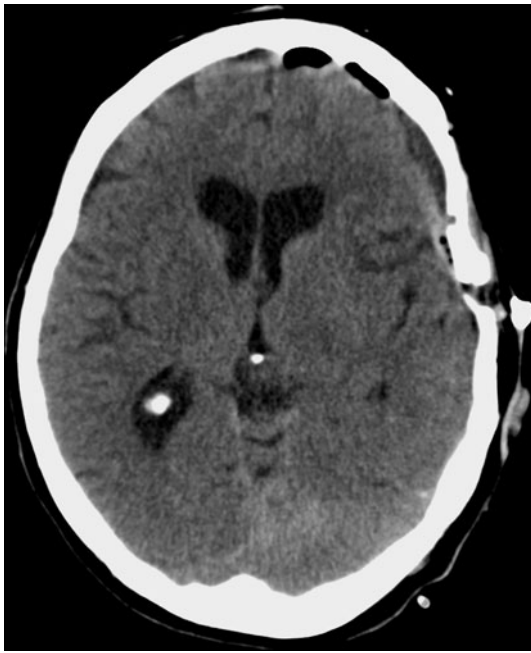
Computed tomography scan of brain in the immediate postoperative period -1
